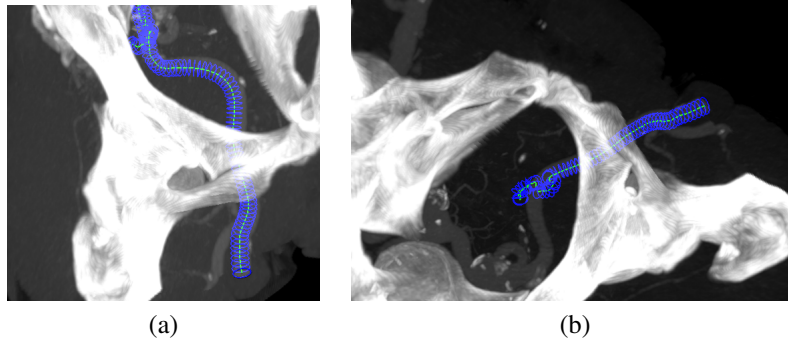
Vascular tracking at multiple-scales in CTA datasets of the abdomen. (a) Result with Hessian estimator and Krissian medialness as strength measure. (b) Result with OOF estimator and Krissian medialness as strength measures.
